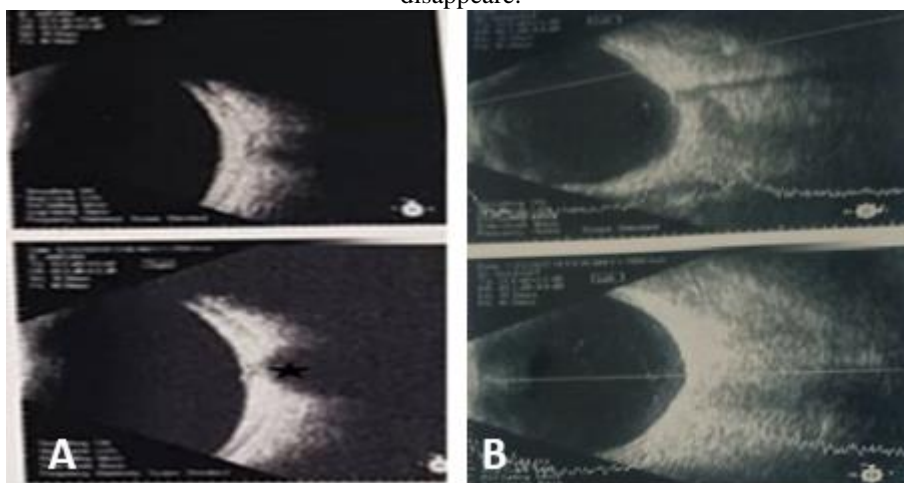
B-scan ocular ultrasonography from right eye before (A) and after (B) treatment show increase posterior scleral thickening and characteristic "T" sign(asterisk), after treatment scleral thickening decrease and "T" sign disappear.
